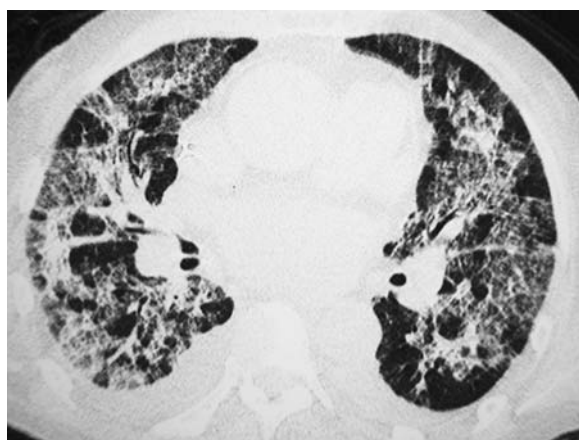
Pulmonary edema due to fluid overload in a 28-year-old woman after allogeneic HSC transplantation. HRCT scan through upper lobes shows smooth septal thickening in a gravity-dependent distribution. The left interlobar fissure is also prominent due to subpleural edema. (With permission from FRANQUET et al. 2005a)
